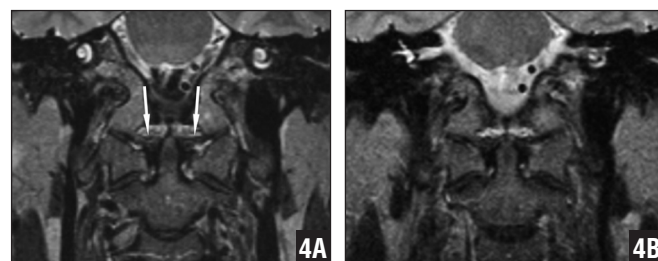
Three-T (A) and 1.5-T (B) magnetic resonance images showing the well-defined borders of the alar ligaments (arrows) on the 3-T image compared with the 1.5-T image.
